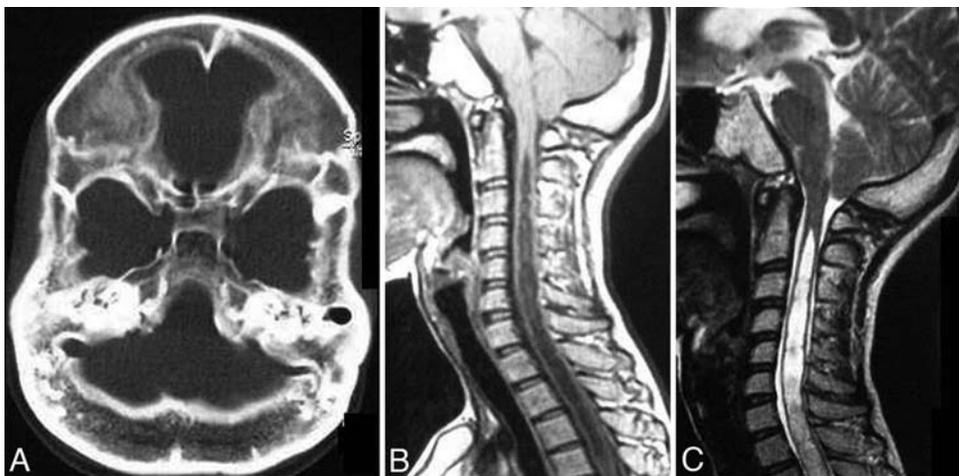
Neuroimages obtained in the affected patient (mother). A: Sagittal CT scan of cranium, upper cervical spine, and face showing diffuse hyperostosis and sclerotic thickening of skull, nasal, and lacrimal bones, with hypoplasia of maxillae and mandibles. Marked hyperostosis of the suboccipital bone can be observed. B: Axial CT scan of the cranium showing diffuse hyperostosis of the skull bones, and the nasal and frontal bones. Reduction in the posterior cranial fossa volume due to hyperostosis of the bones can be clearly seen. C: A T1-weighted sagittal MR imaging study of the craniovertebral junction demonstrating the CM-I and syringomyelia.
